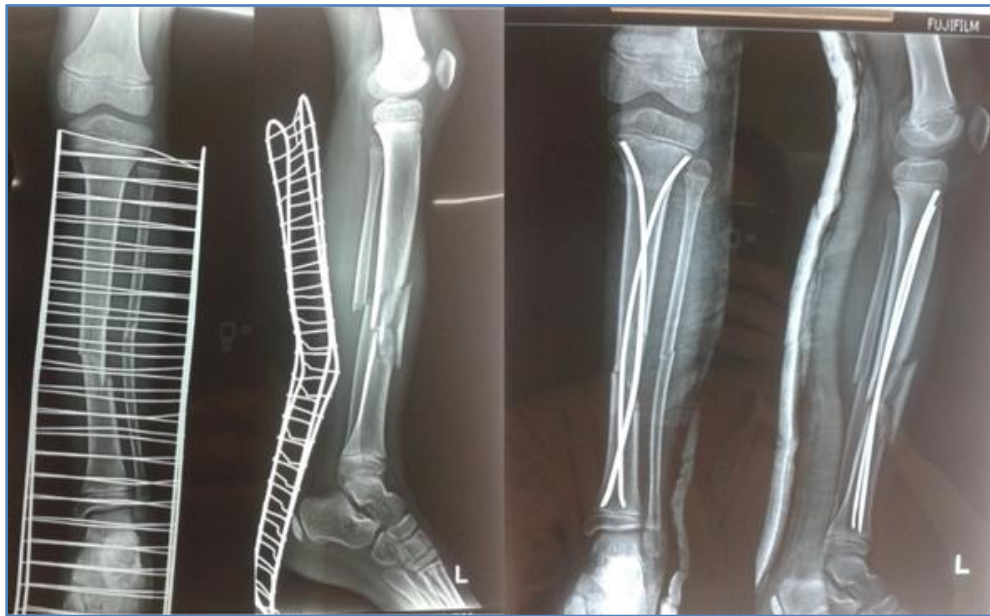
Pre-op and post-op x-ray images of fracture mid shaft tibia treated with TENS
